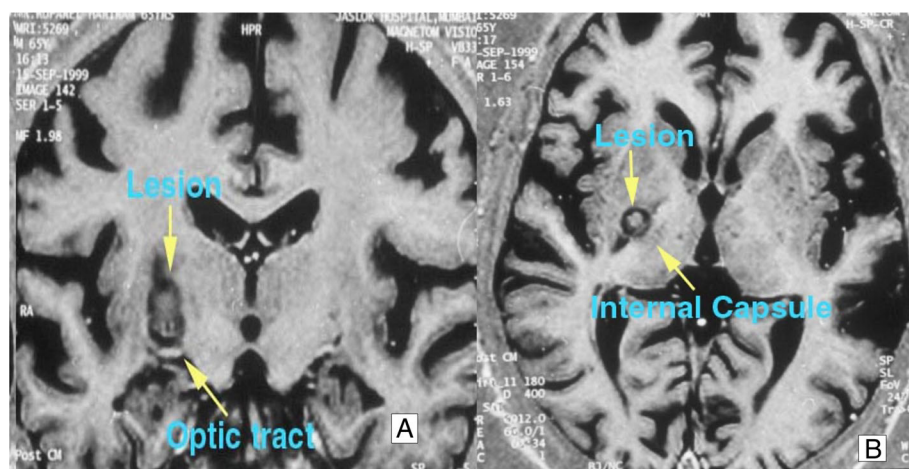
MRI (magnetic resonance imaging) T1-weighted (A) coronal and (B) axial sequence showing lesion in the right pallidum. The lesion borders the inferior margin of the optic tract (A) and the medial margin of the internal capsule (B).
